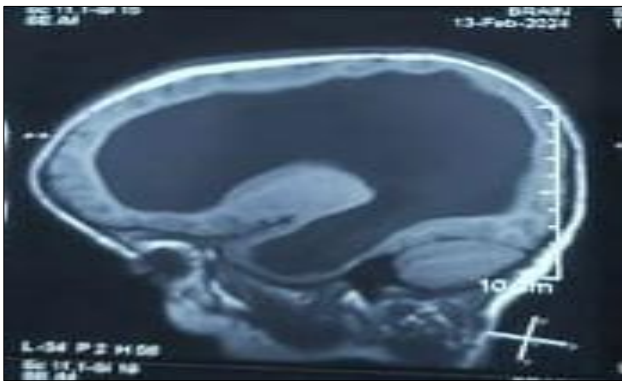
MRI suggestive of bilateral diffuse severe gross dilatation of lateral, 3rd (TD-33 mm) and 4th (TD-26.1 mm) ventricles causing diffuse cerebral parenchymal and corpus callosum thinning.
